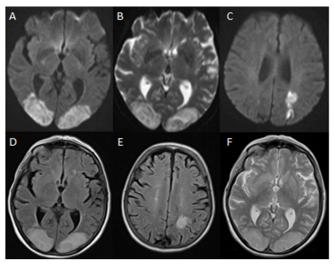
(A-C) Echo planar 2-dimentional diffusion Axial MRI. (D-F) Proton density T2 Axial MRI showing ischaemic changes affecting the posterior occipital and parietal regions symmetrically.
